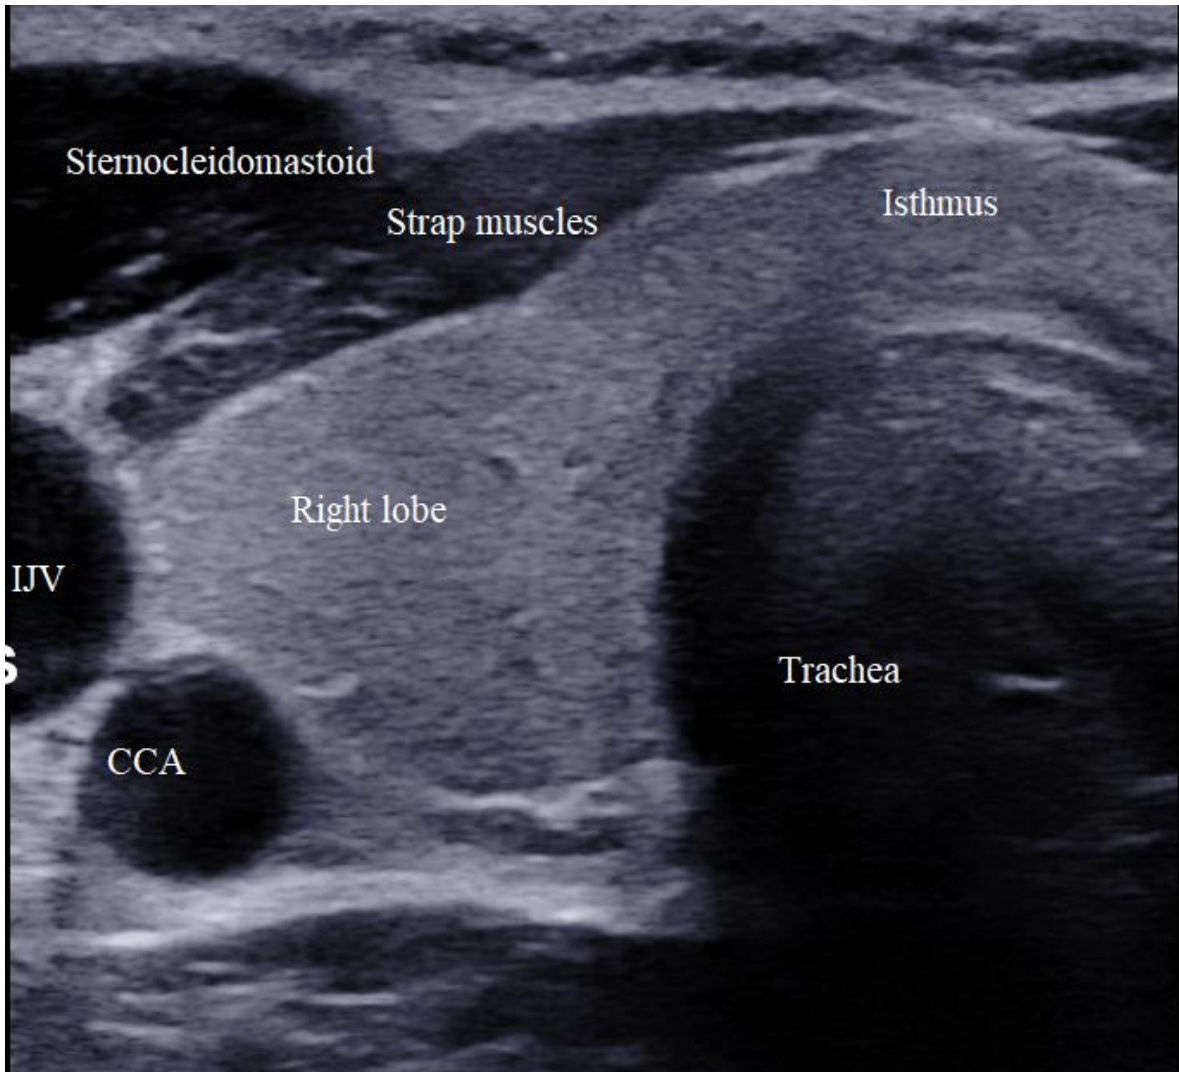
2 A transverse grey scale ultrasound scan of a normal right lobe of the thyroid gland. The adjacent structures such as the trachea, strap muscles, sternocleidomastoid muscle, the right internal jugular vein (IJV) and the right common carotid artery (CCA) are shown.
